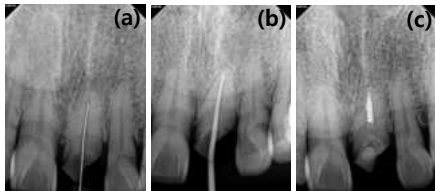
Root canal treatment procedure periapical radiograph on #21
